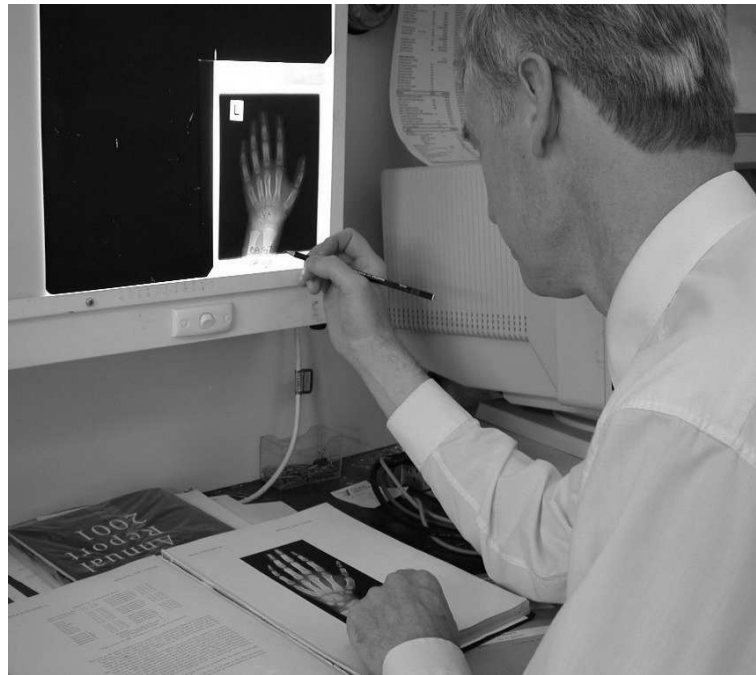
A radiologist reporting a bone age radiograph using the atlas-based Greulich and Pyle method
